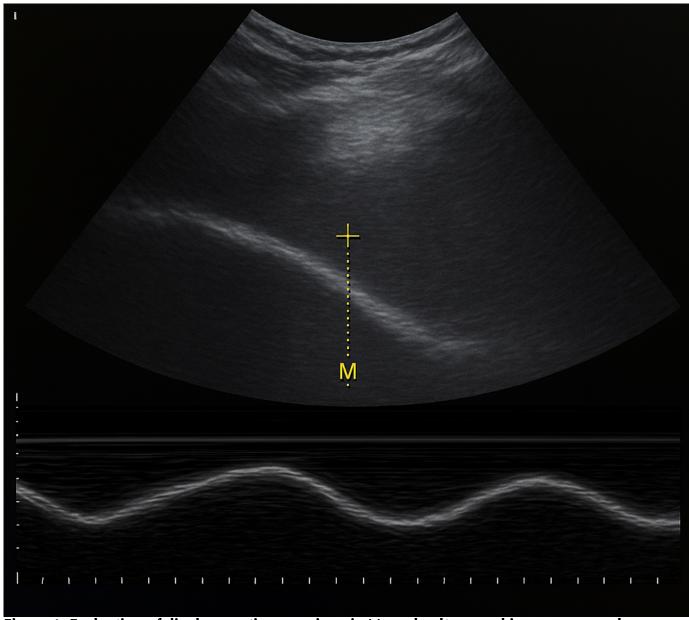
Evaluation of diaphragmatic excursion via M-mode ultrasound in an acromegaly case.
